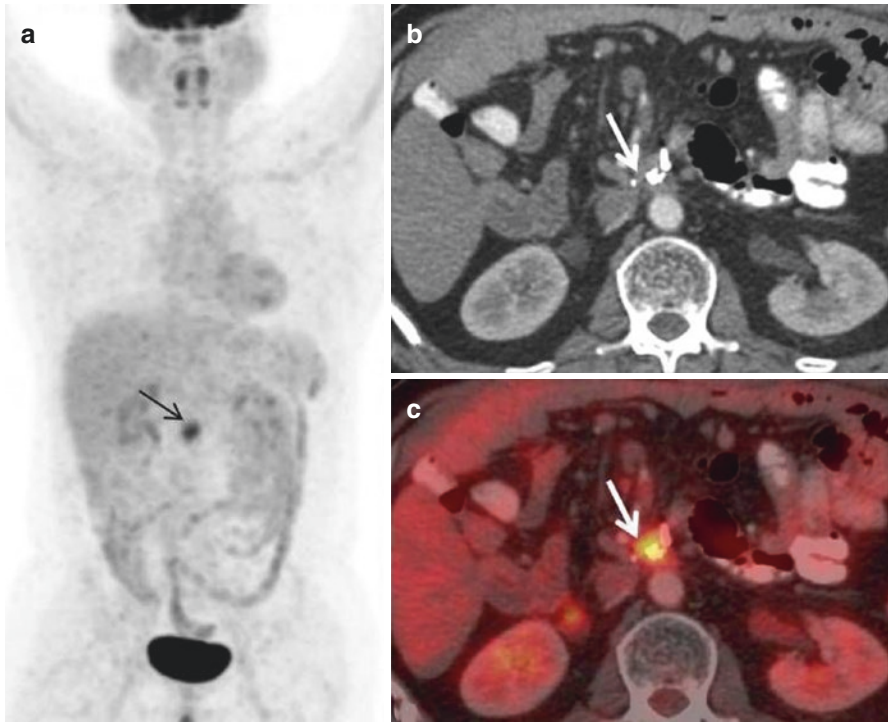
FDG PET/CT for restaging. A 56-year-old female underwent Whipple's procedure for pancreatic adenocarcinoma involving body, followed by adjuvant chemotherapy; 6 months later, presented with rising CA19.9 levels, and hence was referred for PET/CT imaging. MIP image shows focal tracer uptake in the mid-abdomen (*arrow*), which corresponds to FDG-avid soft tissue (*b-arrow*) at the level of SMA origin (*c-arrow*) from abdominal aorta, thus representing local recurrence, with this being a typical pattern of local site recurrence
